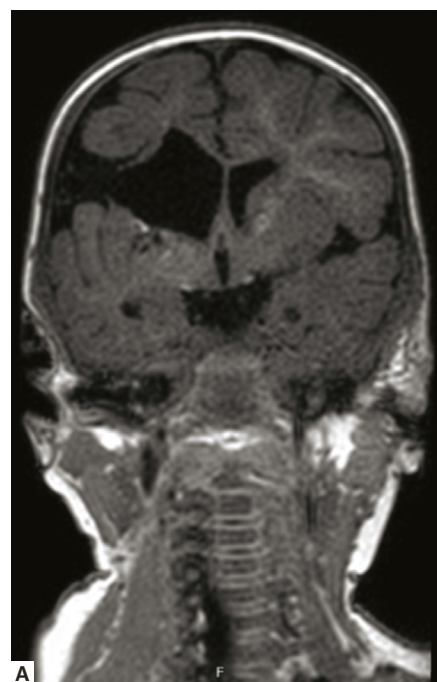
T1-weighted magnetic resonance imaging of this patient showing changes in the right frontal lobe in keeping with porencephaly. A. Coronal view. B. Axial view.
